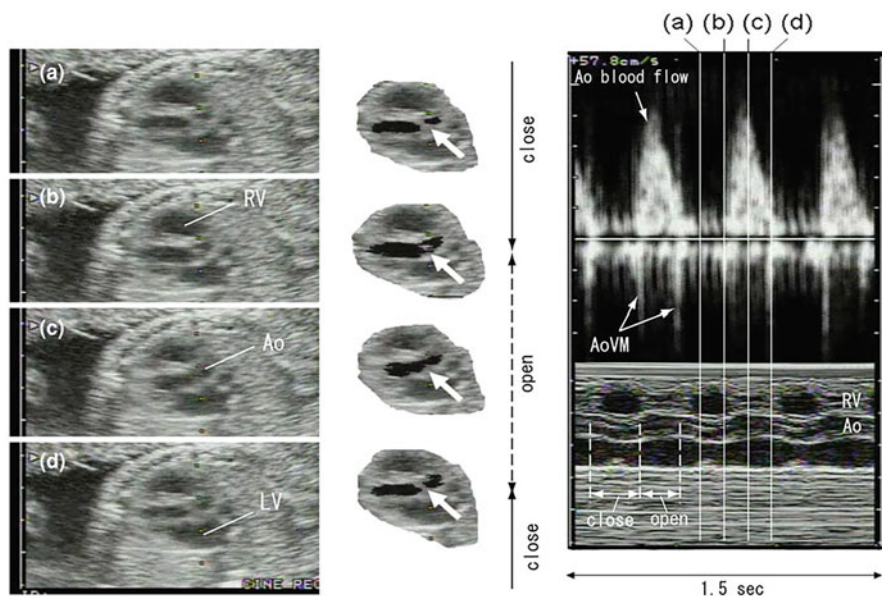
Left panel shows B-mode views of the movements of a fetal aortic valve. Images derived from B-mode views are presented in the middle panels. (a) Ac, (b) onset of Ao, (c) Ao, and (d) Ac [4]. Aortic valve opening and closing are depicted in the right panels in pulsed-wave Doppler mode as well as their M-mode images during the same time phases. Ao aorta, RV right ventricle, AoVM aortic valve movement, LV left ventricle
